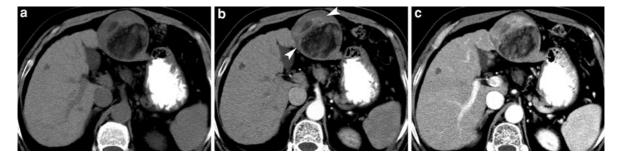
Hypovascular HCC with fatty metamorphosis. a Precontrast CT scan demonstrates an exophytic, fat containing mass lesion in segment 3. b Arterial phase CT scan shows faint
